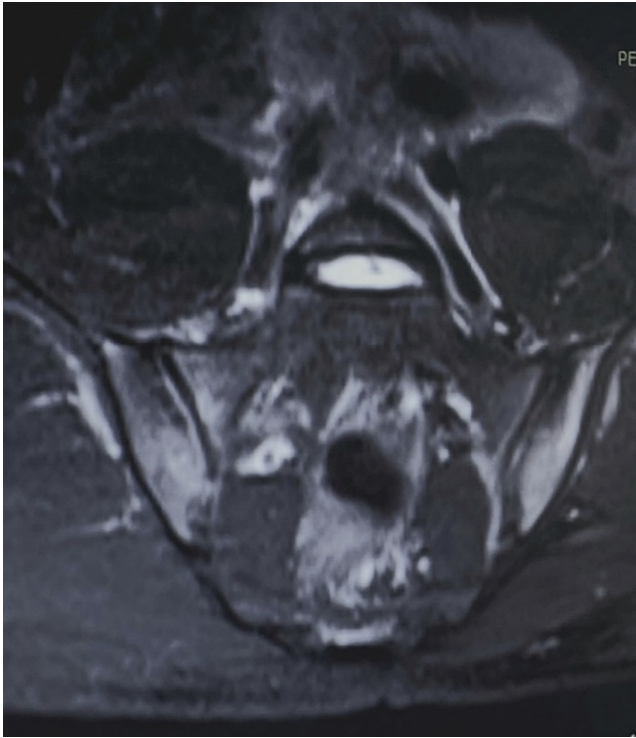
T2-weighted fat-saturated MRI of the sacroiliac joints.
